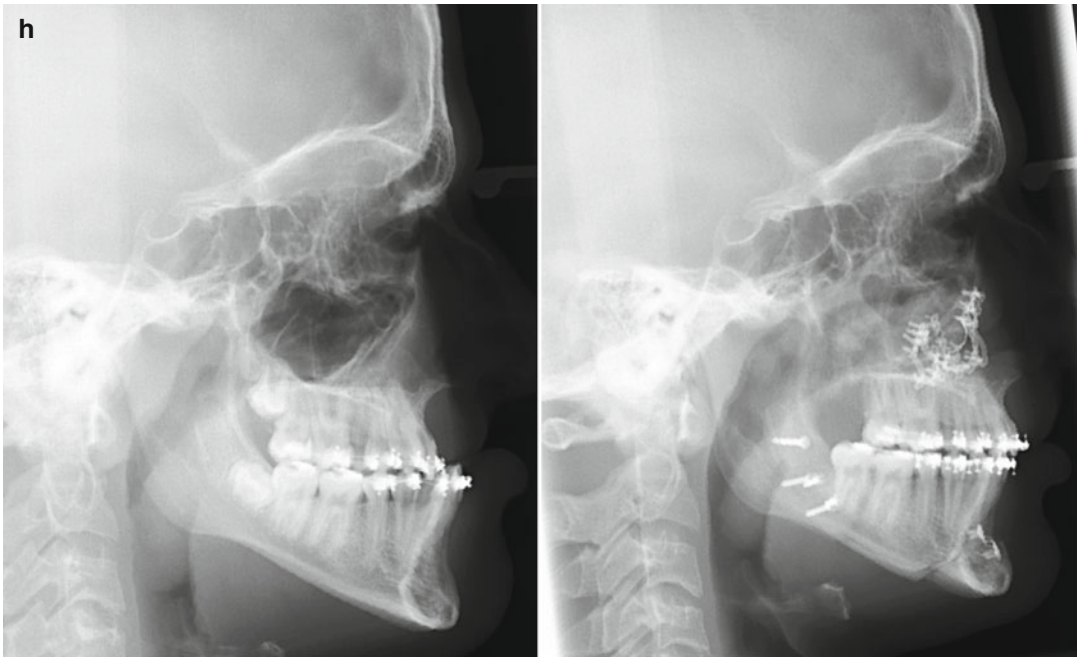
(continued) (h) Cephalometric radiographs before and after reconstruction
